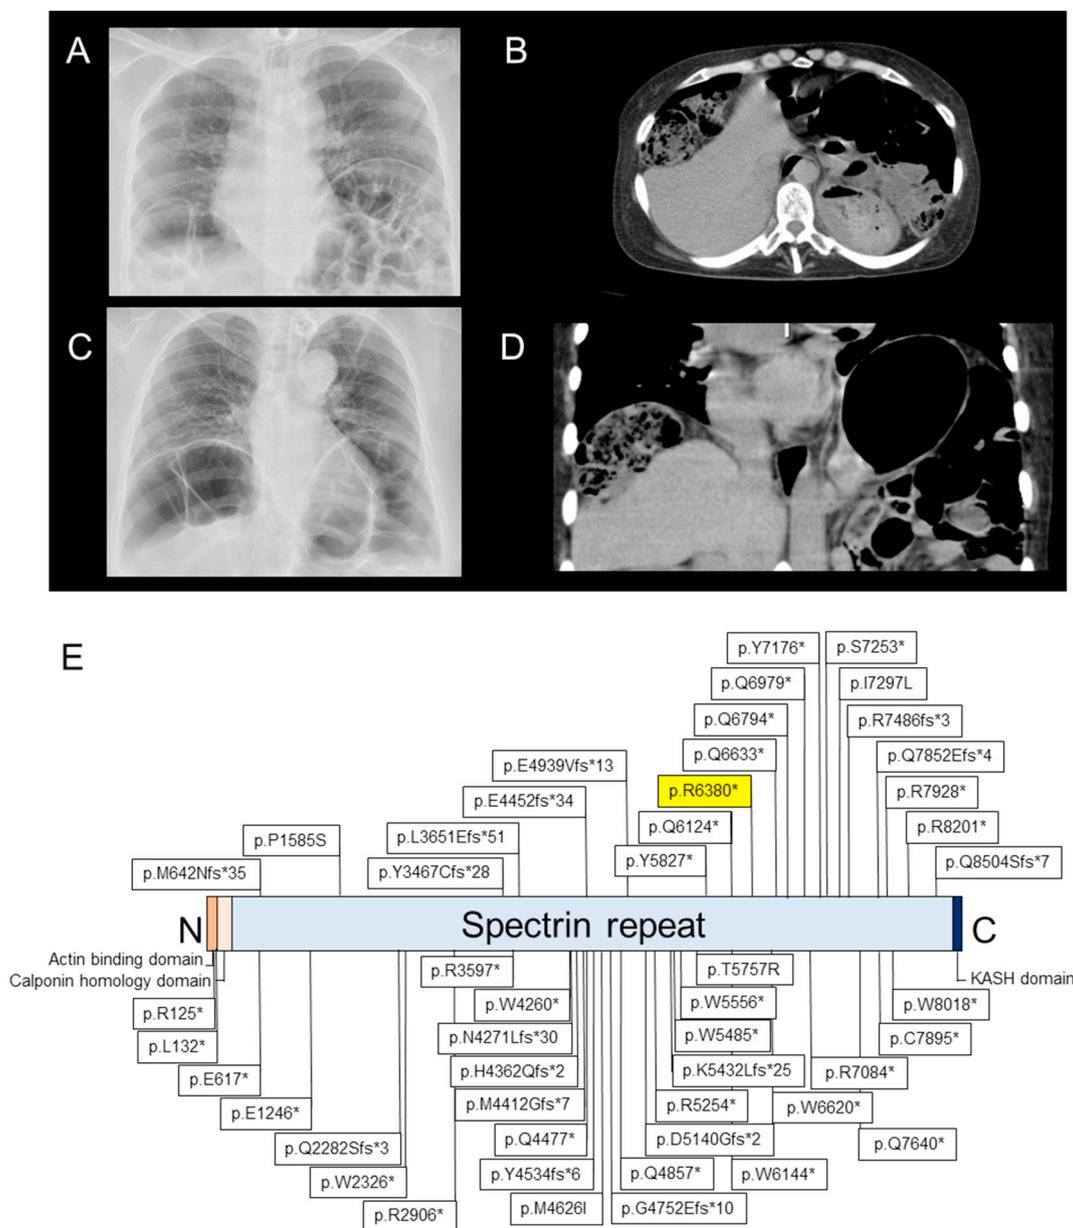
Abbreviations: Spinocerebellar ataxias, SCA; motor neuron disease, MND; Electromyography, EMG; magnetic resonance imaging, MRI; computed tomography, CT; C-terminal Klarsicht/ANC-1/Syne homolog, KASH
